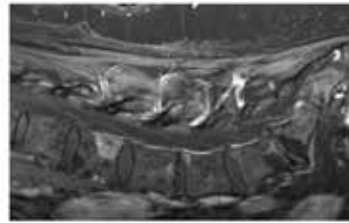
MRI lumbar spine, T1 Dixon sagittal sequence, showing L2 osseous metastasis prior to kyphoplasty in 2021
